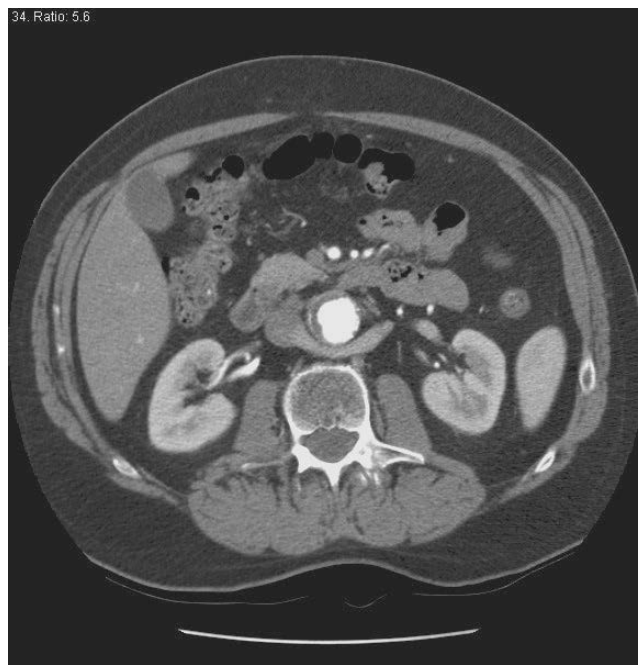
CT scan demonstrating type I retroaortic left renal vein.
